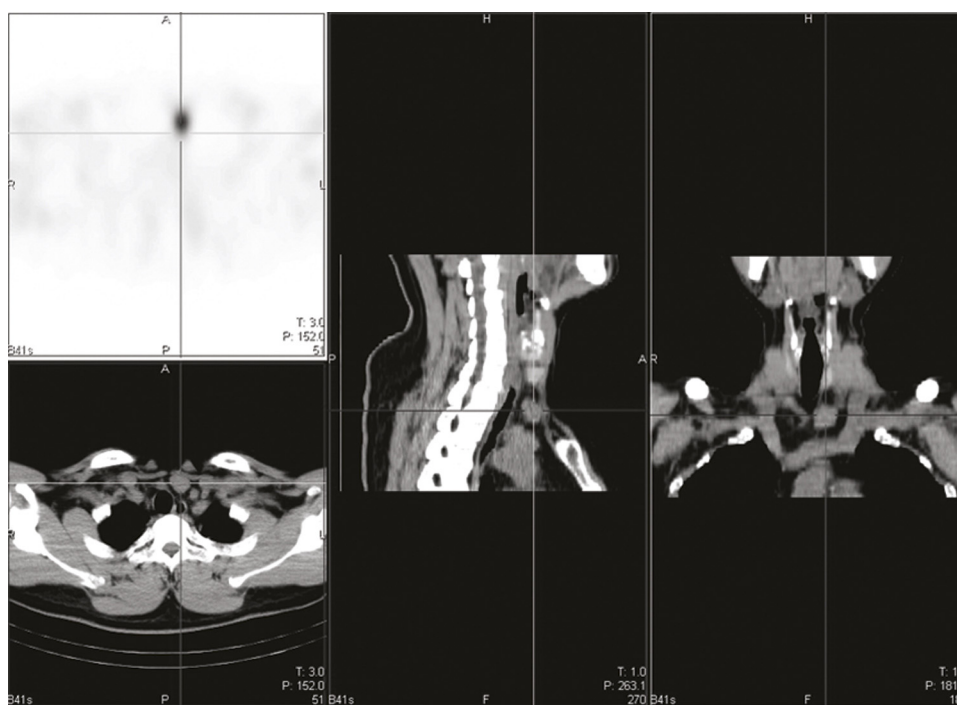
A 62-year-old woman with history of chronic kidney disease treated with hemodialysis. Laboratory tests showed increased serum calcium (21.3 mg/dL) and parathyroid hormone (712 pg/mL) concentrations. Delayed phase of transaxial SPECT (left upper), transaxial CT (left lower), sagittal CT (middle), coronal CT (right) images from 99mTc-sestamibi scan showed abnormal radioactive accumulation in the left upper superior mediastinum. Surgical pathologic result was diffuse parathyroid hyperplasia tissue.
